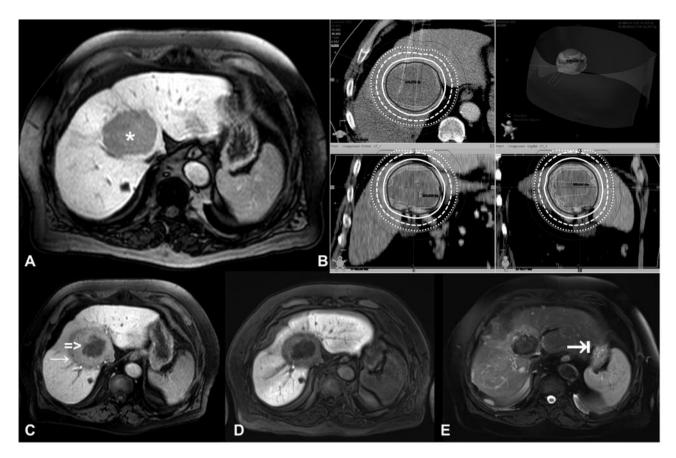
A) Initial gadolinium-ethoxybenzyl-diethylenetriamine penta-acetic acid MRI with primary cholangiocarcinoma (\*), B) radiation plan, grey area = clinical target volume, gray solid line 20 Gy, white solid line 15 Gy, white dashed line 10 Gy, white dotted line 7 Gy, C) 1st follow-up after 8 weeks  $\geq$  shrinking tumor volume,  $\rightarrow$  ablation margin of surrounding liver tissue, D) 2nd follow-up after 5 months, E) 8th follow-up after 30 months with native MRI: T2 Turbo Spin Echo Fat Sat with good local tumor control, but new metastasis in segment 2 ( $\rightarrow$ 1).
